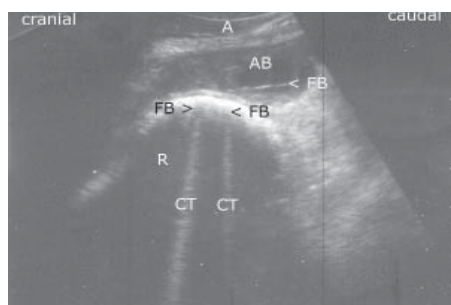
Longitudinal sonogram of 3 foreign bodies perforating the ventral reticular wall. Two of them are imaged in cross section and one in longitudinal section. One of the foreign bodies is seen inside a hypoechoic circumscribed abscess between reticulum and abomasum. A = abdominal wall, FB = foreign body, CT = comet tail artifact, Ab = abscess.
